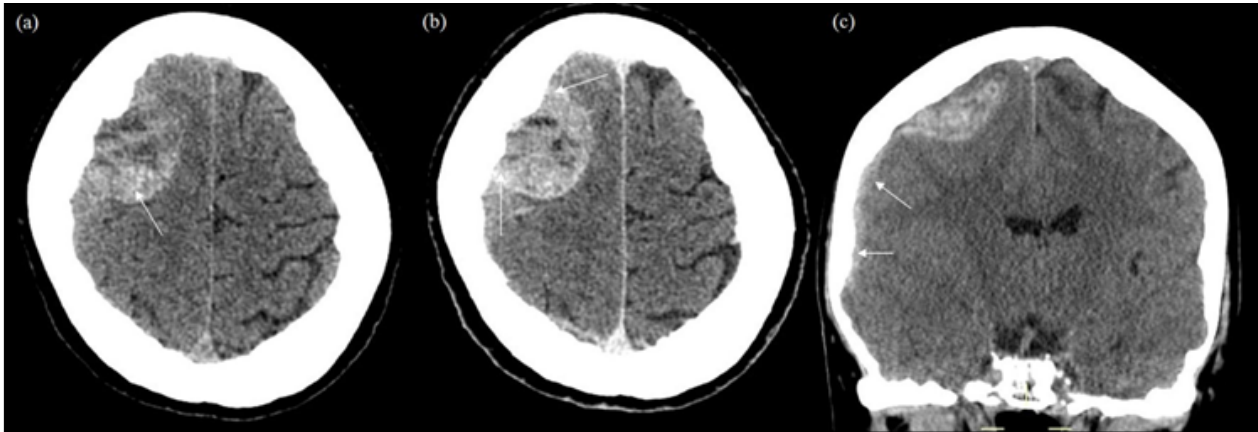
Initial CT scan. (a) Non contrast axial images, (b) Post contrast axial images and (c) Non contrast coronal images. White arrows in (a) show the mass with high areas of attenuation suggesting haemorrhage. White arrows in (b) show enhancement within tumour following contrast. White arrows in (c) show subdural haemorrhage
